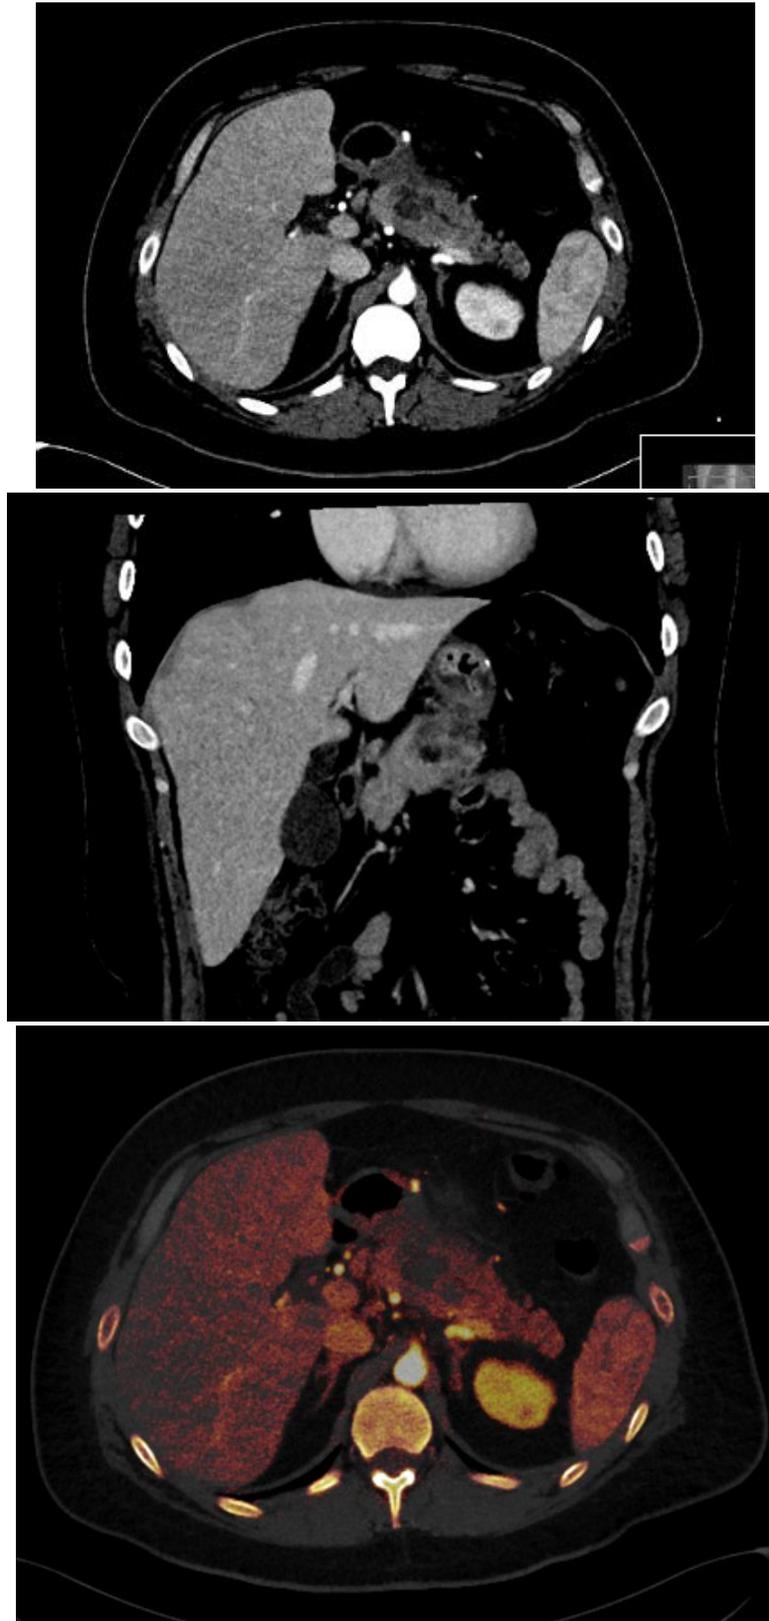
Dual energy contrast enhanced CT study (A) axial late arterial image, (B) coronal late arterial image, (C) axial iodine map image of the upper abdomen showing the interval morphologic change of the mass being currently of predominately cystic component. Notice the hypoenhancement of the lesion and extension into the adjacent gastric wall.
